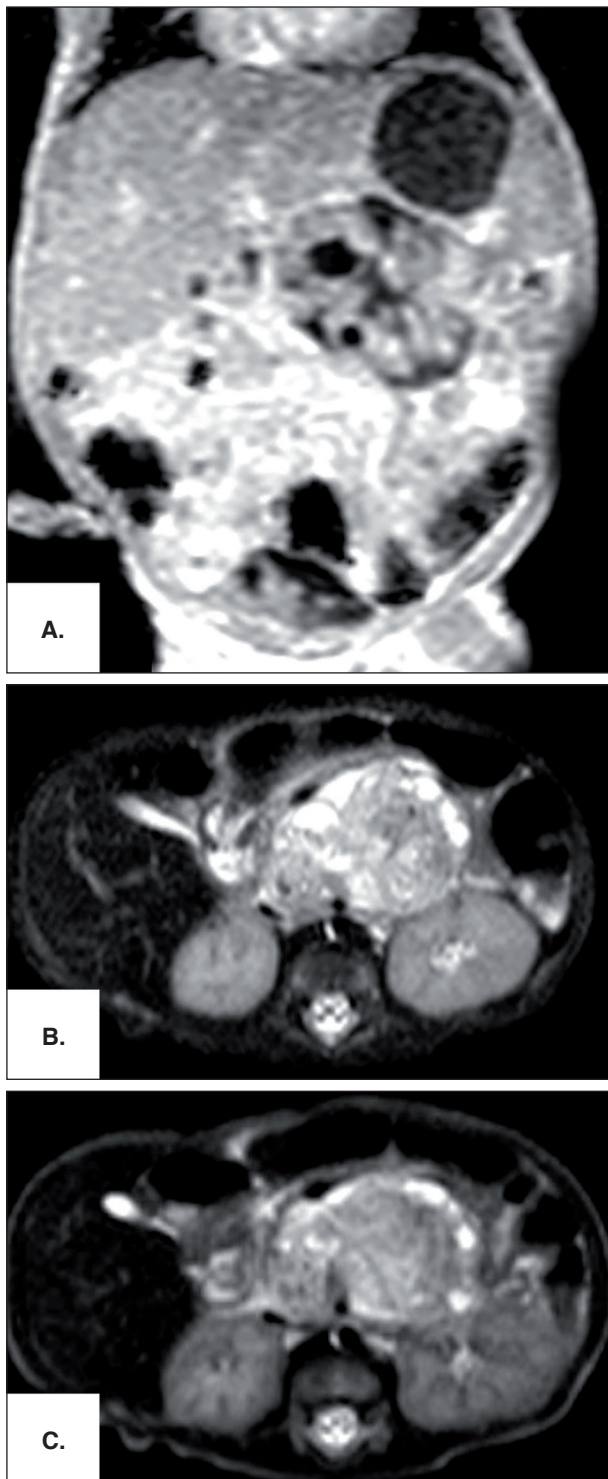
Abdominal magnetic resonance imaging (MRI). It is shown that the mass is located anterior of the abdominal aorta, renal arteries and superior mesenteric artery; between roots of the celiac artery and superior mesenteric artery; behind the superior mesenteric vein, splenic artery and pancreas (A. coronal, B. and C. axial sections).
